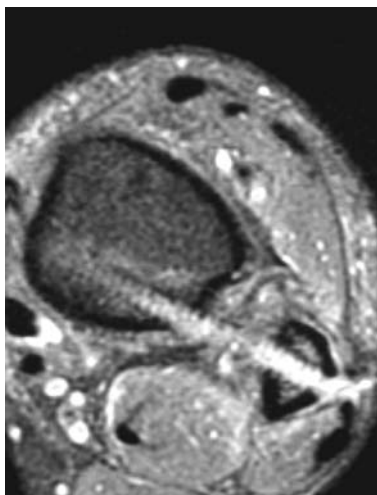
Computed tomography (CT) scan of patient with excessive posterior deviation of the drill bit. Although the screw has purchased the posterior malleolus, the fibula is incorrectly rotated.
